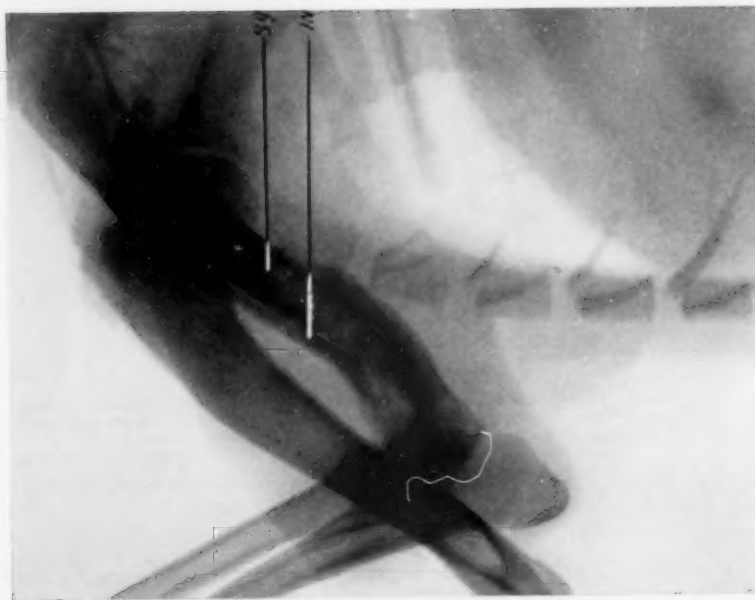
(Path. No. 5942).—Operation October 10, 1919. X-ray November 10, 1919. Large sequestrum with well-marked involucrum and separation zone. *In*, involucrum; *Sg*, sequestrum.
